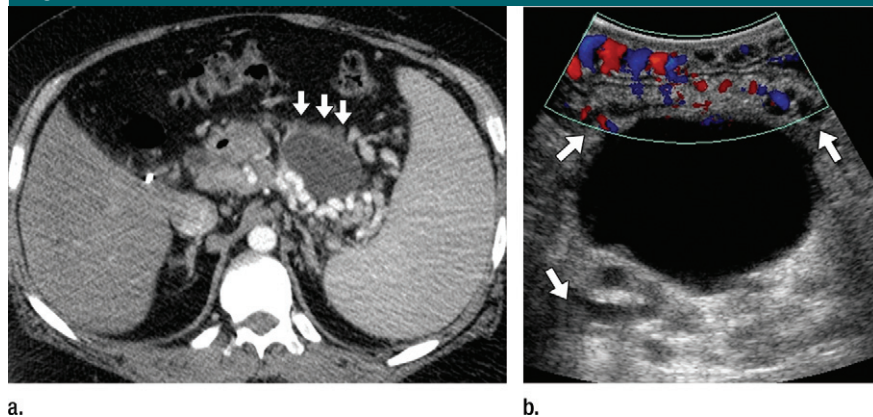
Images in a 37-year-old man with chronic pancreatitis and a symptomatic pseudocyst and splenomegaly who underwent a laparotomy for planned splenectomy and pseudocyst drainage. (a) Preoperative CT angiogram shows varices adjacent to the pseudocyst, as well as a probable safe approach anteriorly (arrows). (b) Intraoperative US images shows numerous large varices surrounding the pseudocyst (arrows), which rendered the lesion unsafe to drain directly, as planned; instead, a transgastric approach was used. Value score of 3.
